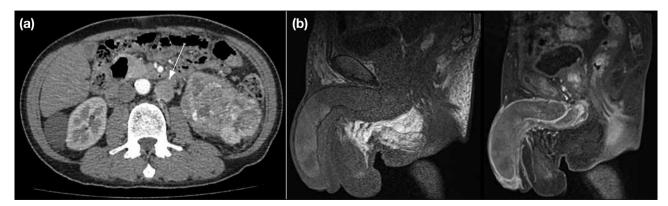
(a) Axial computed tomography image showing an arterial enhancing heterogeneous lesion in the lower pole of left kidney, compatible with renal cell carcinoma. Left para-aortic lymphadenopathy (arrow) is also evident. (b) Sagittal T2-weighted and post-gadolinium T1-weighted magnetic resonance imaging images showing diffuse swelling of the penis with ill-defined areas of heterogeneous T2 signal intensities with patchy enhancement involving the corpus cavernosum and corpus spongiosum.
